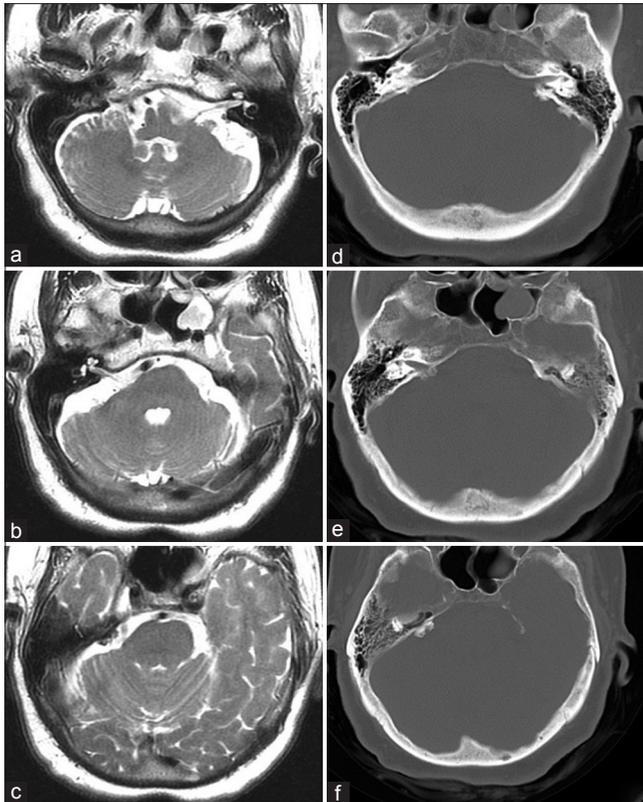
Initial presentation of the patient. Bilateral cerebellopontine angle masses were hypointense to cerebrospinal fluid in axial T2-weighted imaging (a-c), and hyperdense bony lesions were shown in cranial computed tomography scan (d-f)
